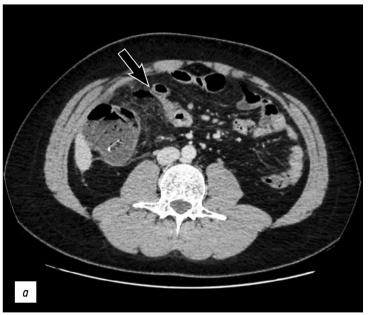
This coronal (*a*) and axial (*b*) pre-contrast computed tomography images showing a blind-ended intestinal loop (arrows) in the right quadrants of the abdomen with associated mesenteric edema and multiple contiguous lymphadenopathies.
